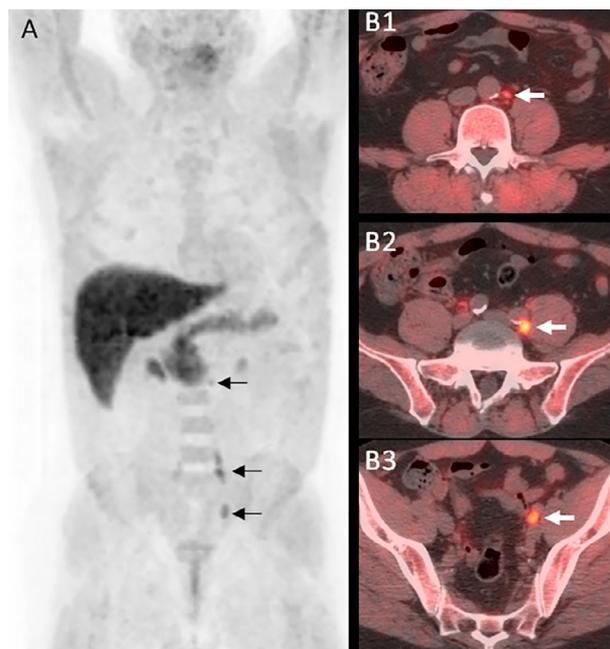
^{18}F -fluciclovine PET/CT imaging in a patient with biochemical recurrence prostate cancer (PSA of 5.25 ng/mL). Maximal intensity projection (A), and axial fused ^{18}F -fluciclovine PET/CT (B) images show abnormal foci of uptake fusing to subcentimeter left paraaortic (B1), left common iliac (B2), and left internal iliac lymph nodes (B3).
